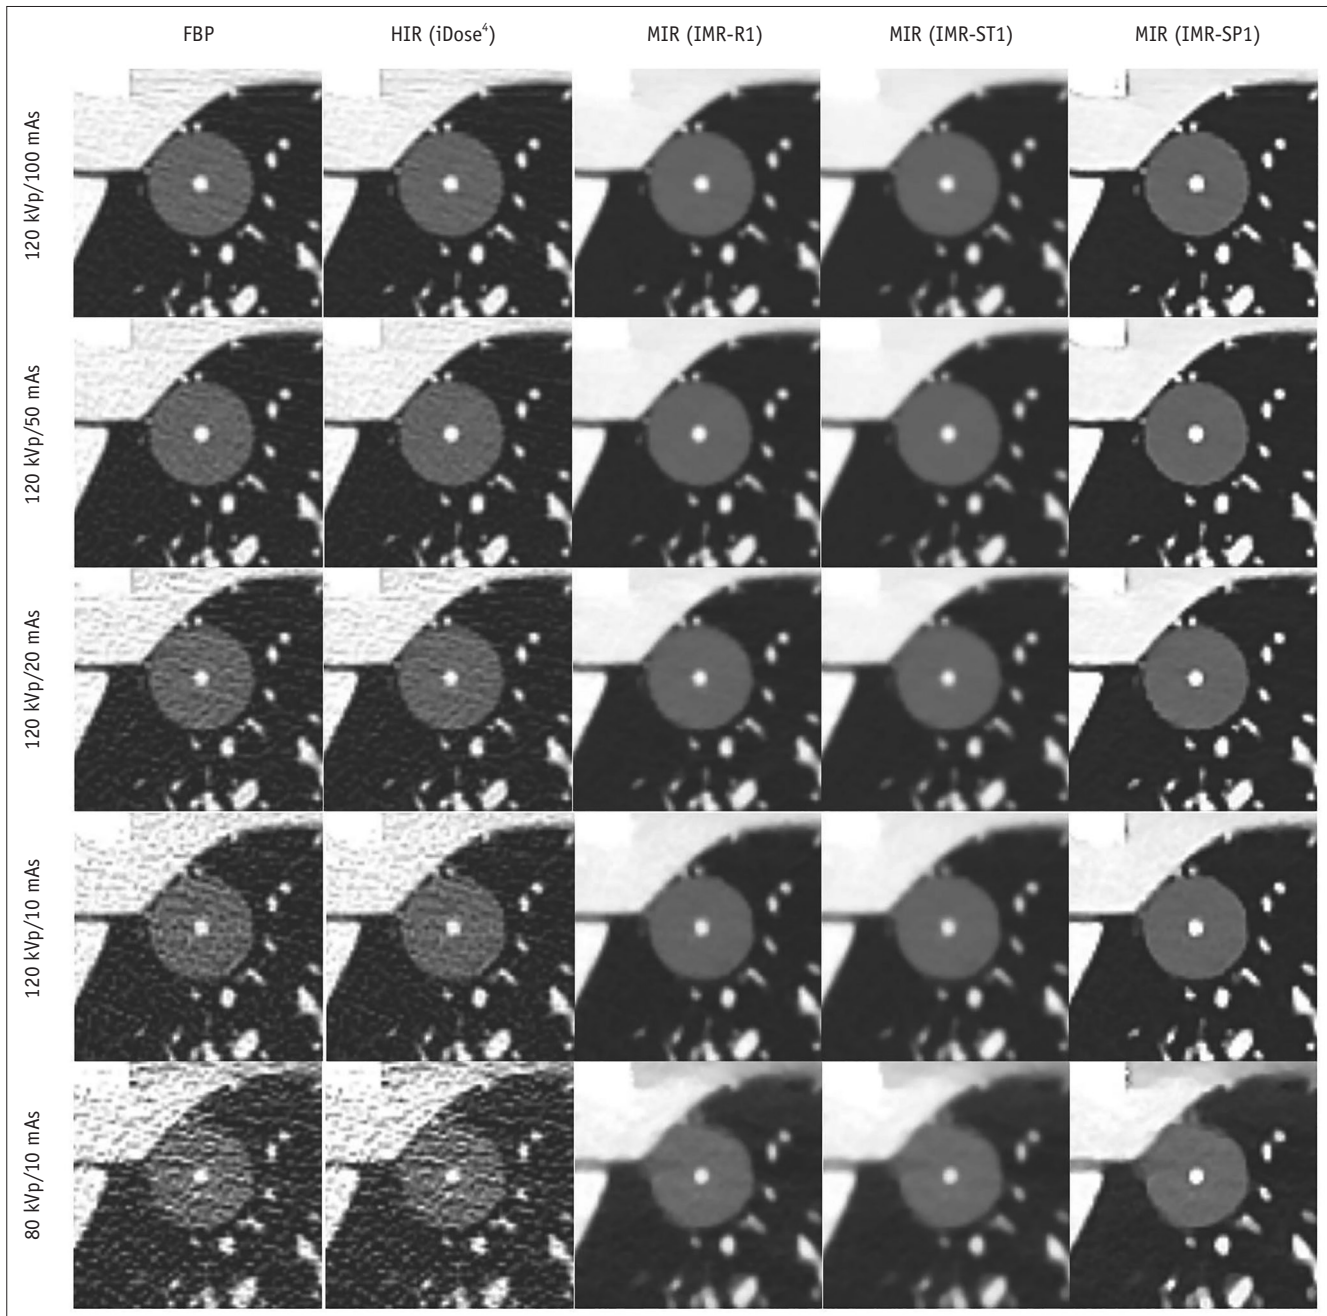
CT images of PSNs at different radiation dose settings. Images of PSNs (outer GGO portion, 20 mm; inner solid portion, 3 mm) at five radiation dose settings reconstructed with FBP, HIR (iDose⁴), and MIR with three different image definitions (IMR-R1, IMR-ST1, IMR-SP1). HIR = hybrid iterative reconstruction
